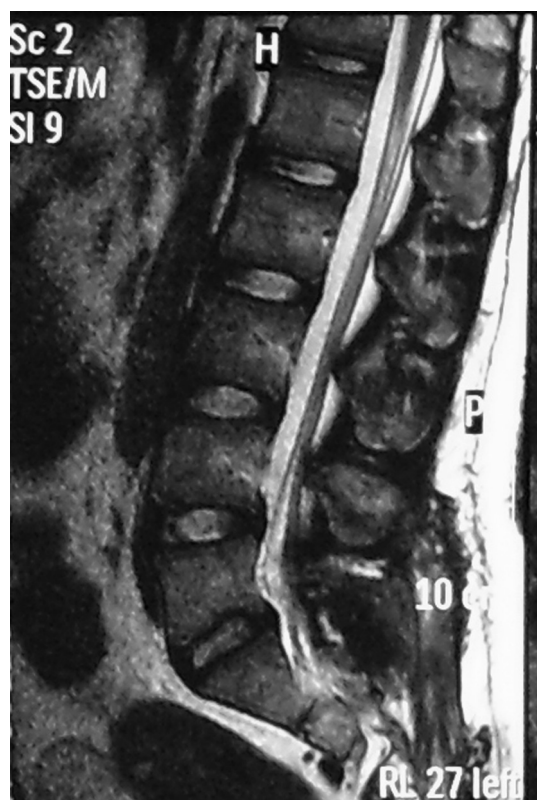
Sagittal T-2 weighting MR image at the postoperative third month of stab injury shows resolution of the knife track.
